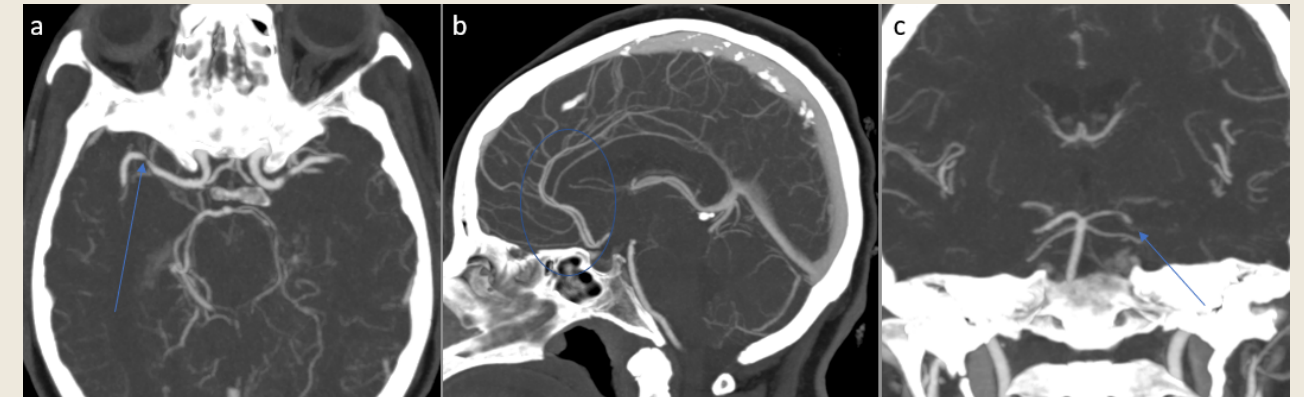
Six-week follow-up CTA of the head. (a) Axial view showing some persistent narrowing of the right M1 segment, but with interval resolution of the dilation originally identified. (b) Sagittal view demonstrating no residual A2 or A3 narrowing or dilation. (c) Coronal view revealing persistent involvement of the left PCA.
